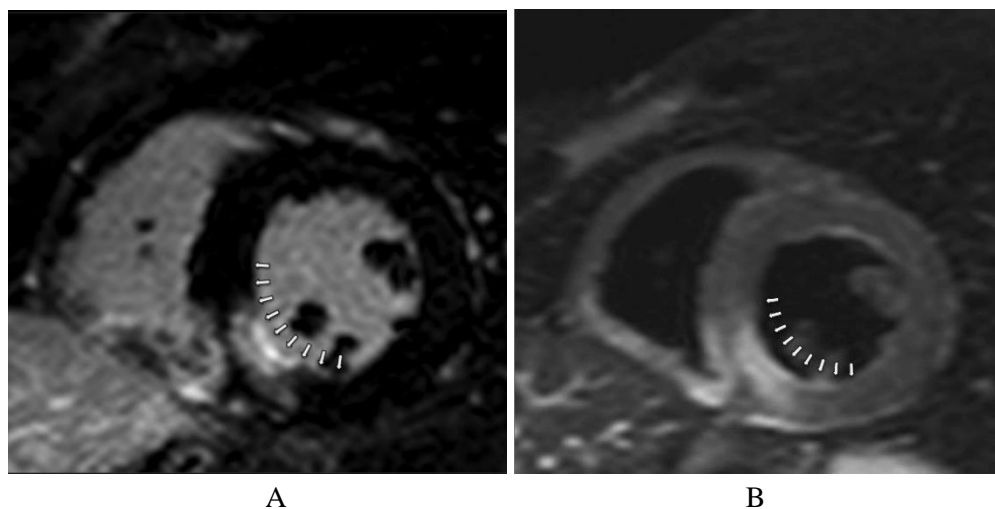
Ischemic cardiomyopathy. A) Late gadolinium enhancement imaging. The arrows indicate the transmural LGE distribution. B) T2-weighted sequences. Arrows indicate edema of the inferior wall, inferior septum and the inferior wall of the right ventricle.
